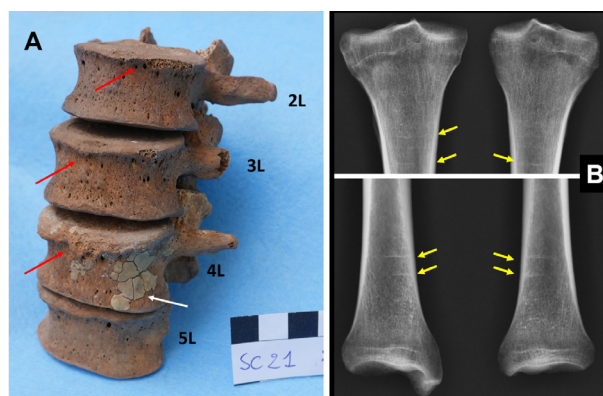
A: lumbar tract of the spine showing some waxy patches (white arrow) and a slight osteophytosis affecting the superior edge of vertebral bodies (red arrows); B: X-ray of both tibiae showing the Harris lines (yellow arrows).
